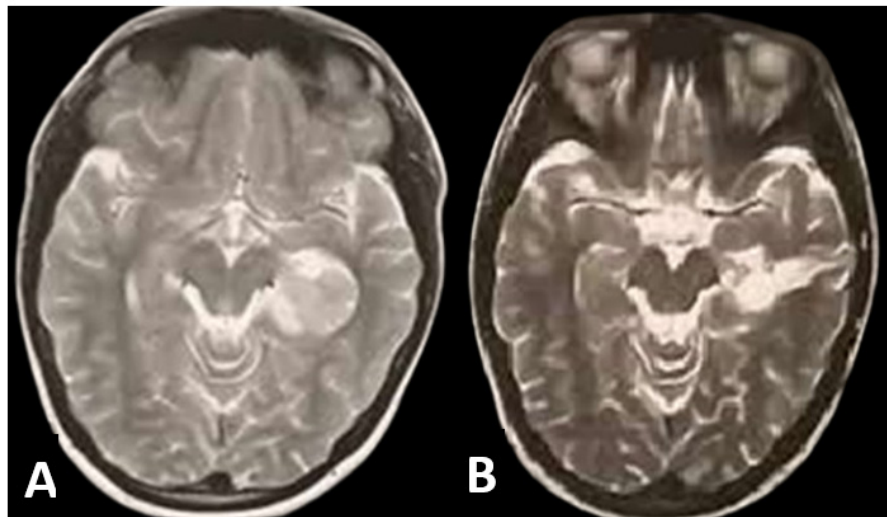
(A) Preoperative axial MRI (T2 sequence) showing left temporal horn intraventricular space occupying lesion and (B): Post-operative axial MRI brain (at 3 months follow up) showing gross total resection of the lesion.
